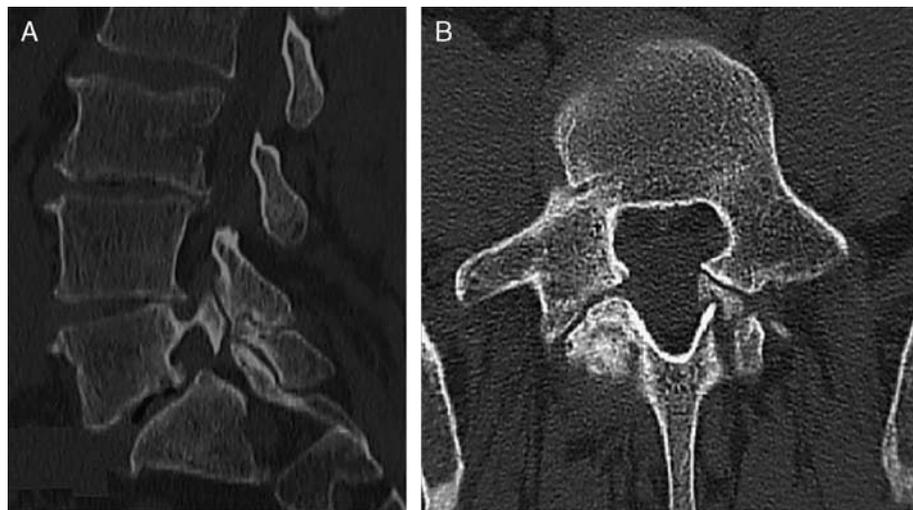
Preoperative computed tomographic scan showing spondylolisthesis at L5–S1 and pars fractures at L5. A, Sagittal view. B, Axial view.
